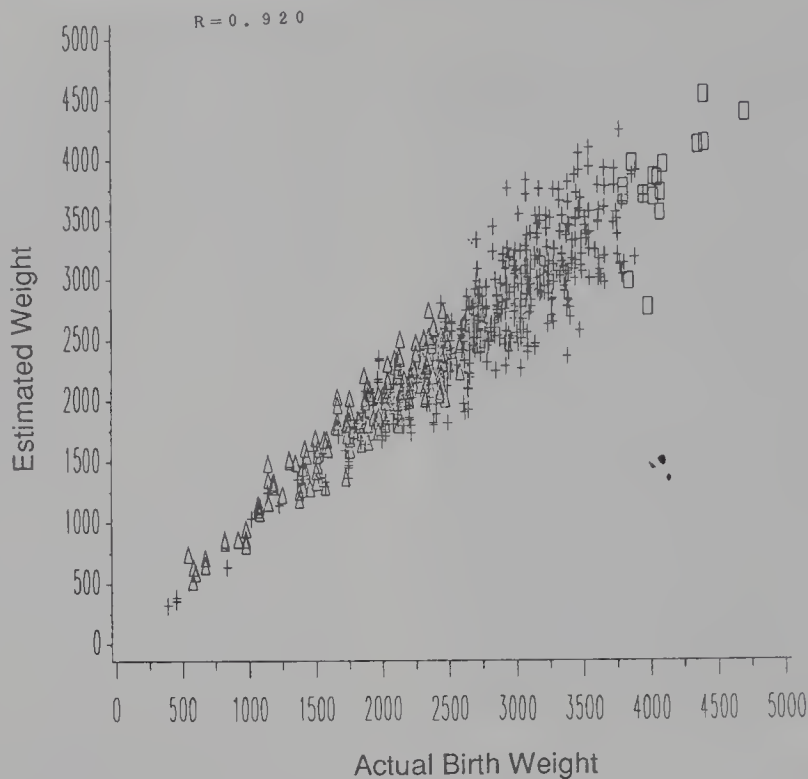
Correlation between estimates of fetal weights by ultrasound and actual birth weights by the Shinozuka formula. Key: Δ , light-for-dates; +, appropriate for dates; ‡, heavy-for-dates. With permission from Norio Shinozuka, MD, University of Tokyo.
